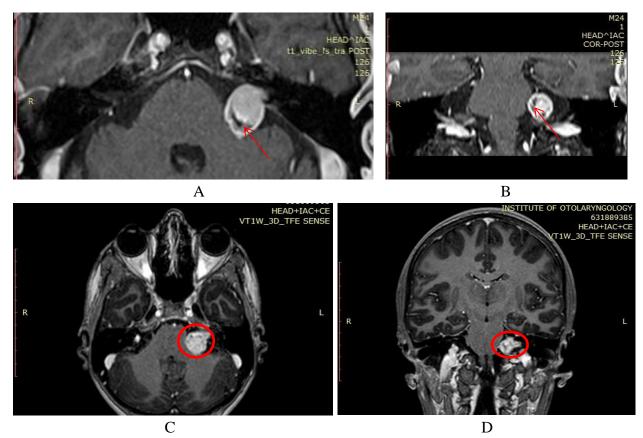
T1 MRI images with contrast revealing: A, B - cystic appearance of the tumor in a patient with stage II VS; C, D - cystic type tumor under the aspect of "ice cream cone" in a patient with stage III VS.
